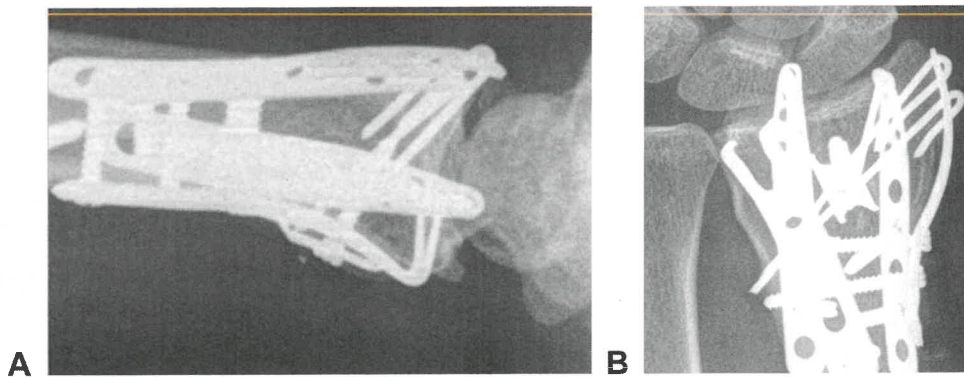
Postoperative radiographs (A lateral, B posteroanterior) show maintenance of articular congruity and stabilization of the volar ulnar fragment.
